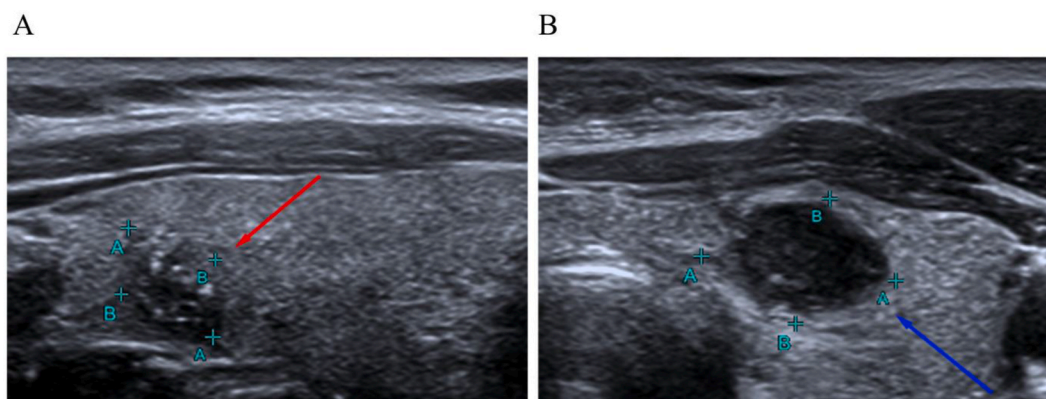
The ultrasonic imaging features of PTC patients with BRAF^{V600E} mutation A: BRAF^{V600E} mutation positive: the nodule with ill-defined margin, the shape is irregular, taller-than-wide shape ≥ 1 (Red arrow in the Figure); B: BRAF^{V600E} mutation negative: the nodule with defined margin, regular shape, taller-than-wide shape < 1 ; (blue arrow). These ultrasonic nodules come from patients who were diagnosed as PTC pathologically. A+ and B+ are the long diameters and short diameters of the nodules. (For interpretation of the references to colour in this figure legend, the reader is referred to the Web version of this article.)
